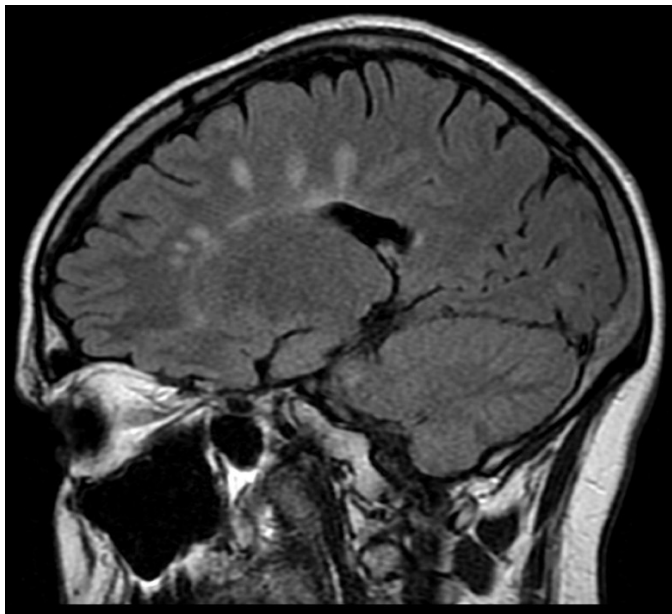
MRI-scan, sagittal fluid-attenuated inversion recovery (FLAIR) show: multiple white matter hyperintensities (demyelinating lesions), some of them are perpendicular to the corpus callosum. Typical appearance for multiple sclerosis
